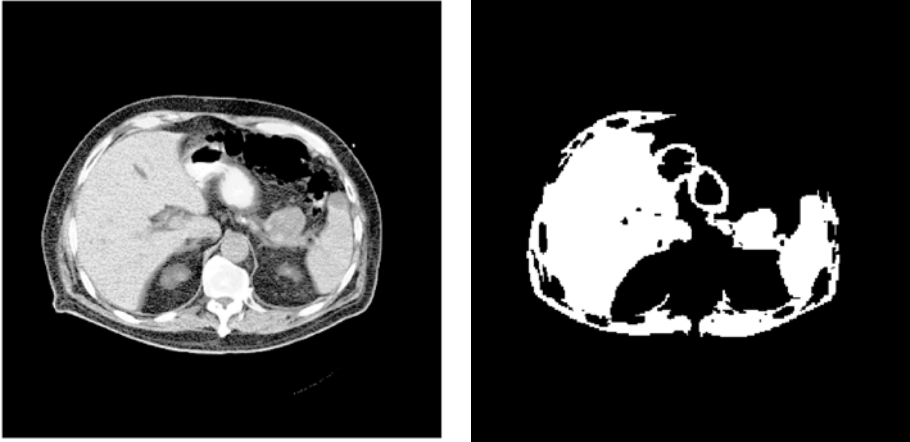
(a) Original helical, contrast enhanced CT slice with a pancreatic tumor at the tail of the pancreas indicated by white arrow. (b) Region based segmentation using ITK software on Fig. 4.7(a).
